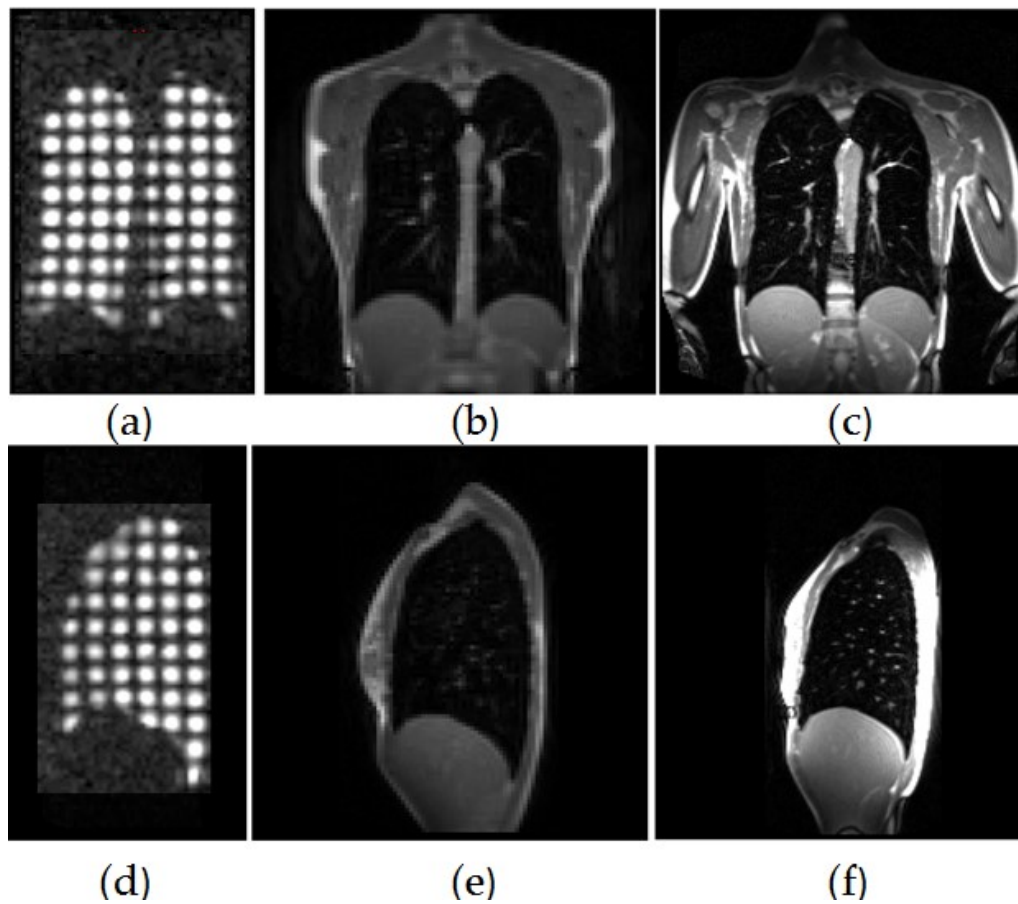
Top are examples of MR images in coronal view for (a) HP He-3 Tagging MR, (b) low-resolution proton MR, (c) high-resolution proton MR. Bottom are MR images in sagittal view for (d) HP He-3 Tagging MR, (e) low-resolution proton MR, (f) high-resolution proton MR.
